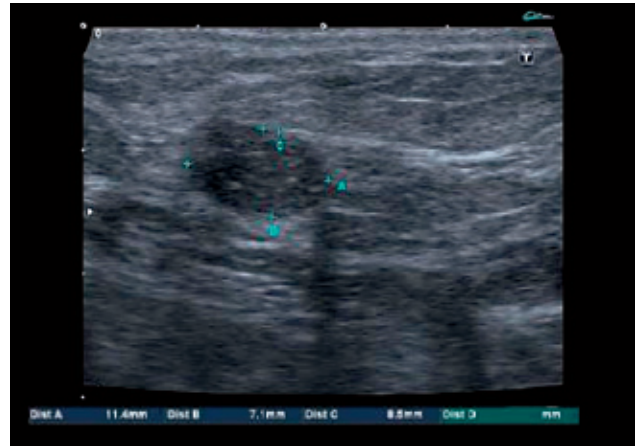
Ultrasound image on screen.
